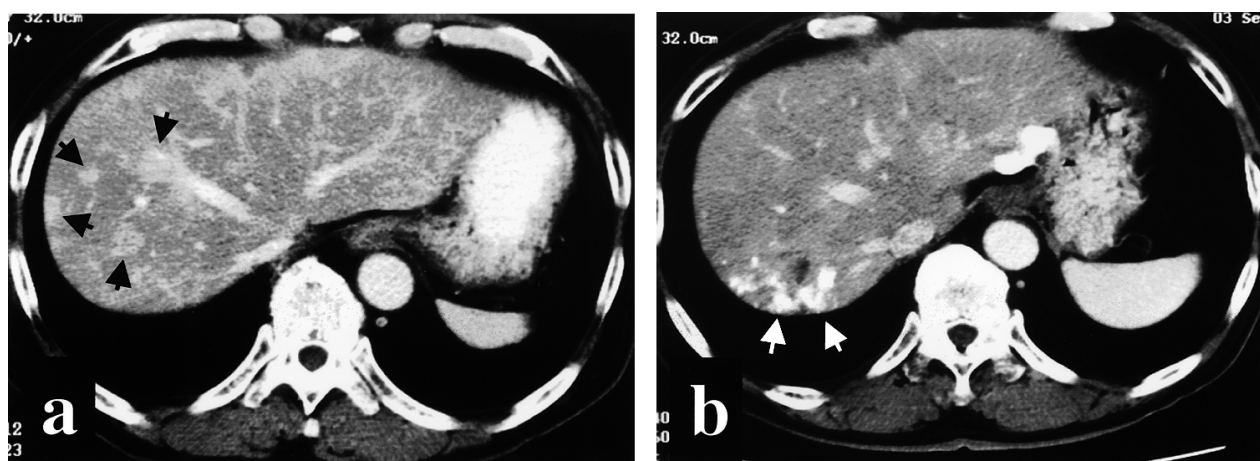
CT scan with contrast medium before (a) and after TAE (b). The metastatic liver tumor was enhanced with contrast medium on CT scan before TAE (black arrows), while Lipiodol but not metastatic tumor tissue was visualized as a high density area after TAE (white arrows).
